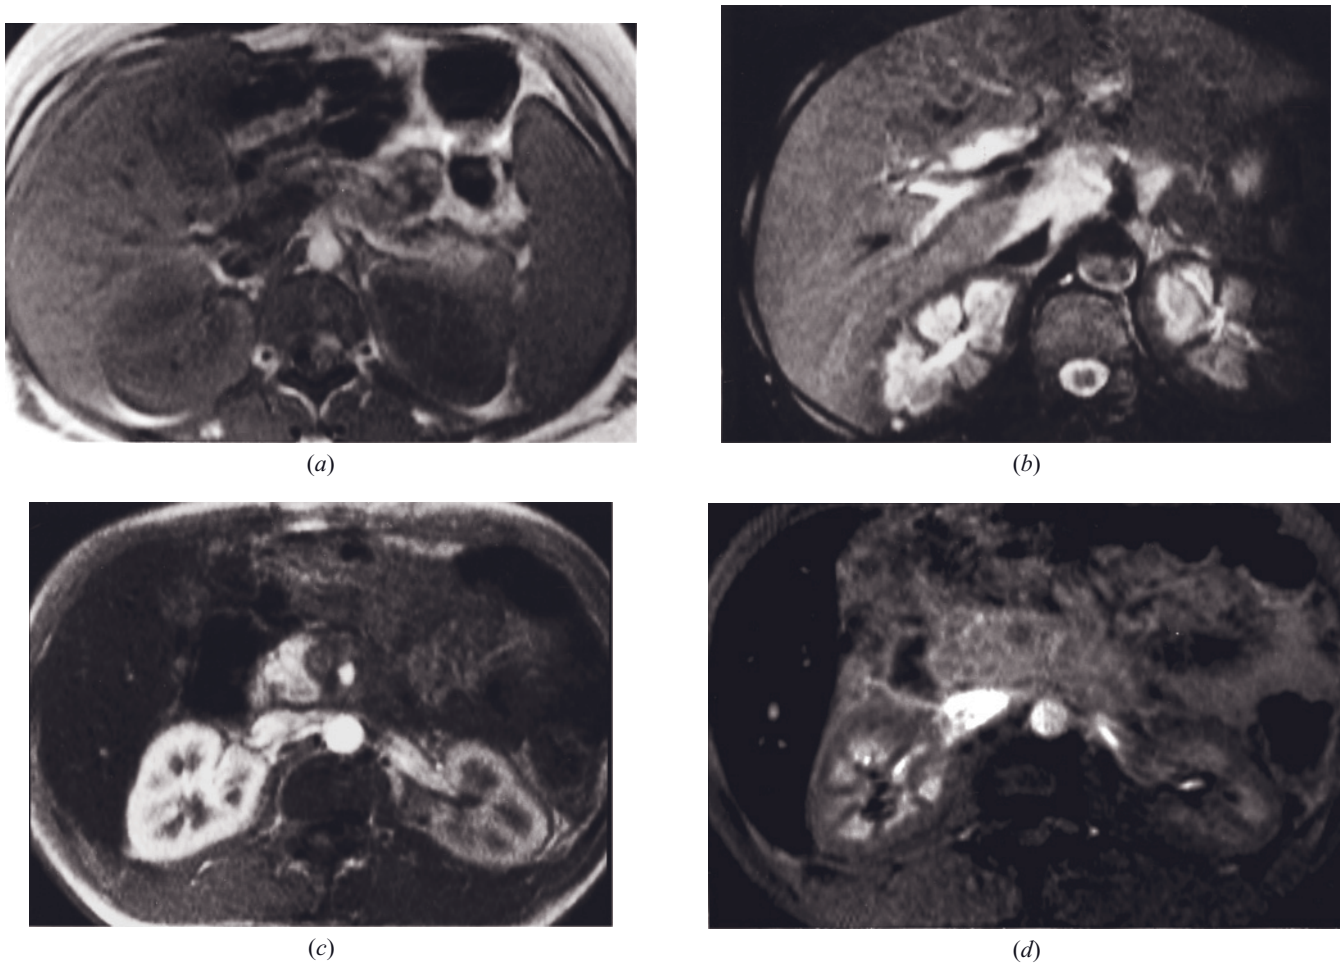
Sick cell disease. T1-weighted precontrast SGE (a) image demonstrates preservation of CMD in a patient with sickle cell disease because of the presence of dilute iron in the renal cortex that results in a T1-shortening paramagnetic effect. T2-weighted fat-suppressed SE image (b) in a second patient demonstrates low signal intensity of renal cortex secondary to accumulation of free hemoglobin. High-signal-intensity celiac and porta hepatic nodes are also present. T1-weighted immediate (c) and 2-min (d) postgadolinium SGE images in a third patient. On the immediate postgadolinium image (c), the renal cortex is high in signal intensity, which reflects that the T1-shortening effect of gadolinium exceeds the T2-shortening effects of iron. At 2 min after injection (d), the T2 shortening effect of iron in the cortex exceeds the T1 shortening effect of gadolinium, causing diminished signal intensity of the cortex. The relative washout of gadolinium from the cortex coupled with the transit of gadolinium into the medulla results in this signal reversal of cortex and medulla. Signal intensity changes in renal parenchyma on postgadolinium images in patients with sickle cell disease reflect the changing balance of T2-shortening effects of iron and T1-shortening effects of gadolinium.
